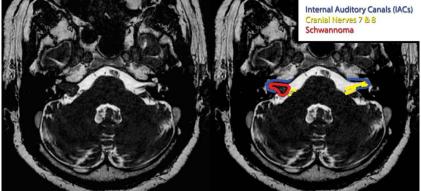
Axial FIESTA MRI sequence. University of Massachusetts Medical School, Department of Radiology.
